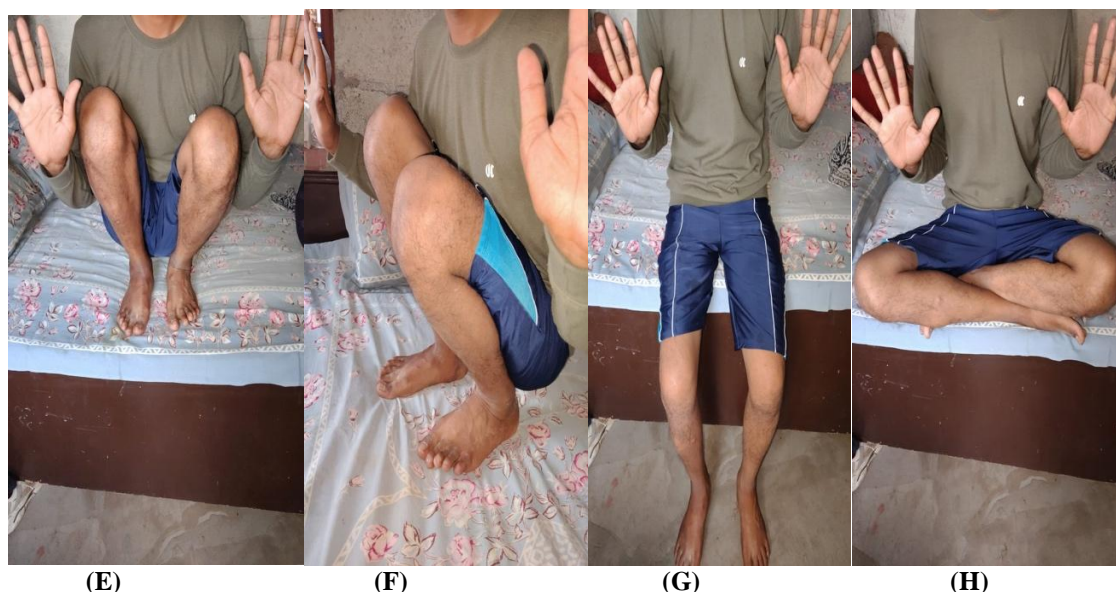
Representative case of floating knee injury managed surgically. (A) Preoperative radiographs showing ipsilateral femoral and tibial fractures. (B) Postoperative radiographs showing fixation of femur and tibia. (C, D) Follow-up radiographs showing maintained alignment and fixation. (E–H) Clinical photographs showing functional recovery of knee flexion and sitting ability during follow-up.
